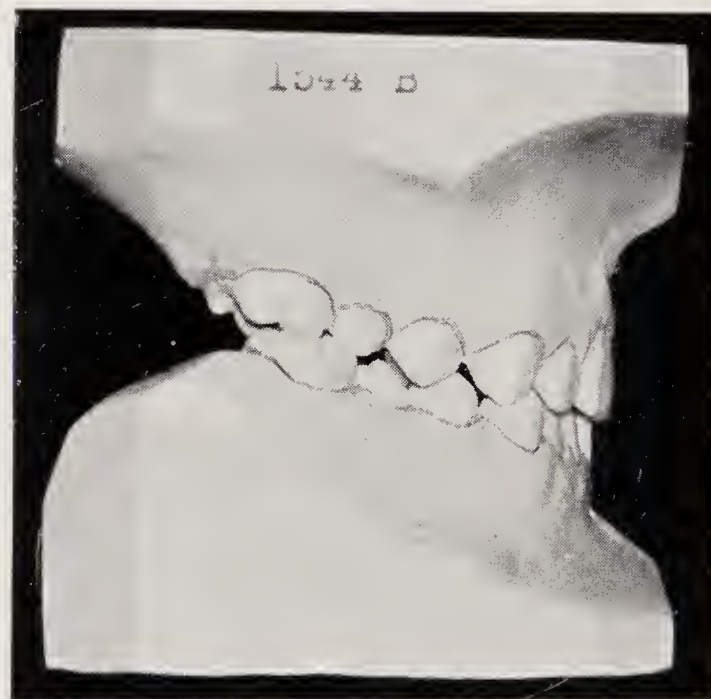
Case 1544. Age $9\frac{1}{2}$. Angle Class III. Treatment with sliding activator from January 14, 1952 to February, 1954. A, Superimposed tracings of lateral radiographs. B, Models at commencement and completion of treatment.
